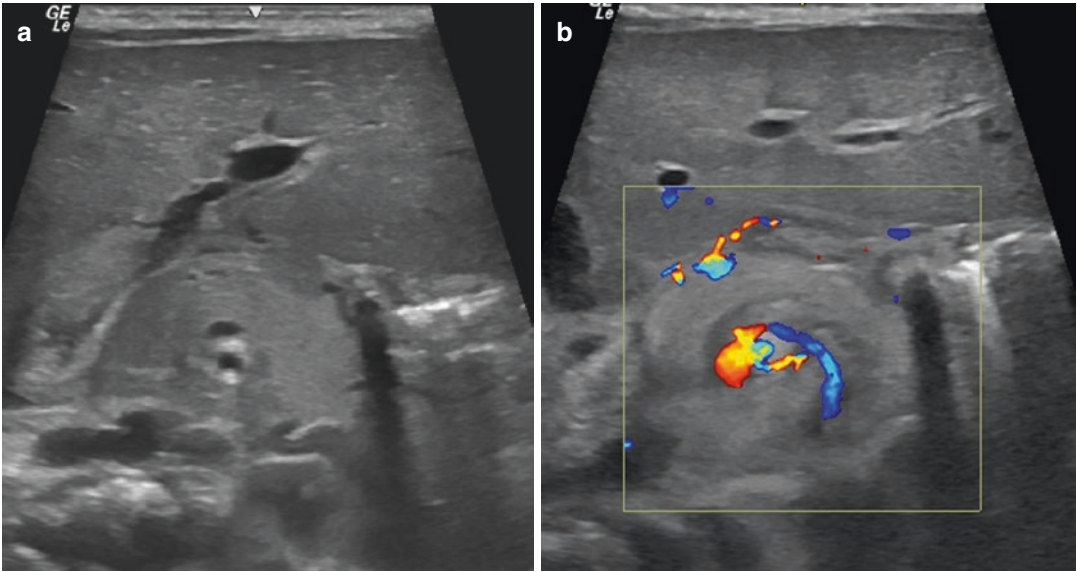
Midgut volvulus: (a) Transverse US scan of the epigastric area showing the displaced mesenteric vein (*arrow-head*). (b) Showing a typical color Doppler whirlpool sign
